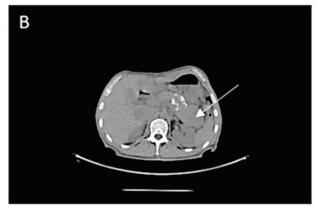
Computed tomography scan of the abdomen showing multiple liver metastasis (A) and a mass in the pancreatic tail (B).
